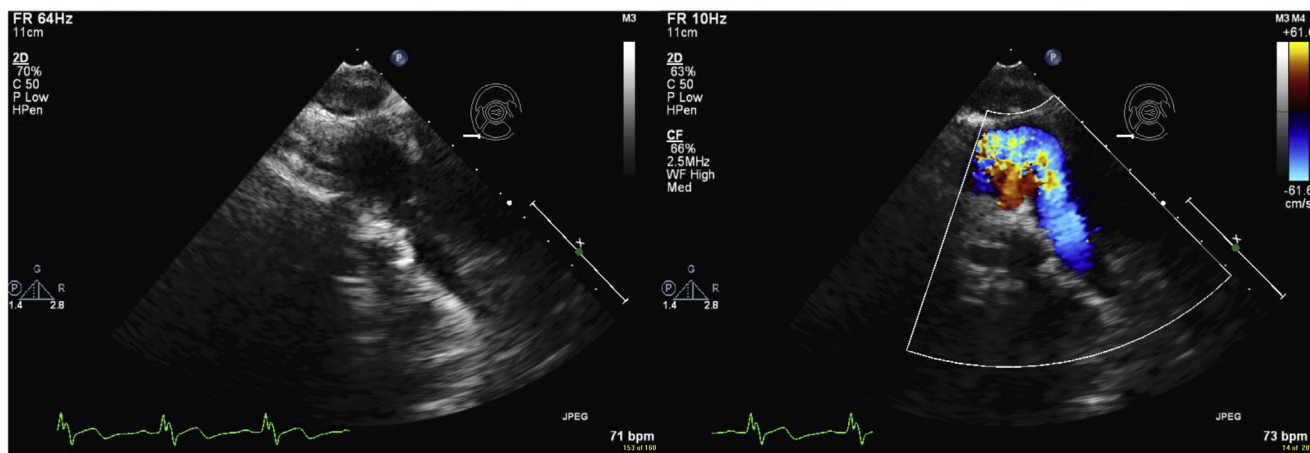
Transthoracic echocardiogram showing the right ventricular to pulmonary artery (RV-PA) conduit without (L) and with (R) colour Doppler flow displaying no identifiable vegetation.
